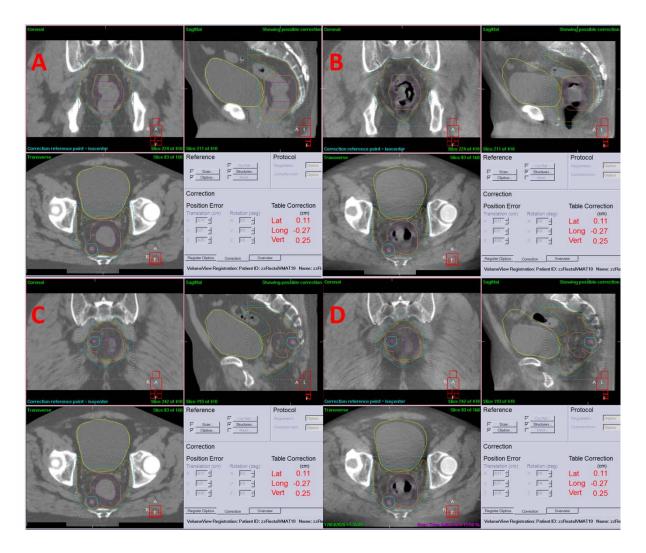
Example of treatment plan with SIB volume. Figure 7a and Figure 7b show the planning CT and CBCT at the level of the GTV; Figure 7c and Figure 7d show the planning CT and CBCT at the level of the nodal tumour volume. Despite the smaller bladder volume evident on the CBCTs compared to the CTs, the GTVp and GTVn (GTVn_Boost) are well covered by the PTV_High and PTV_Low.
